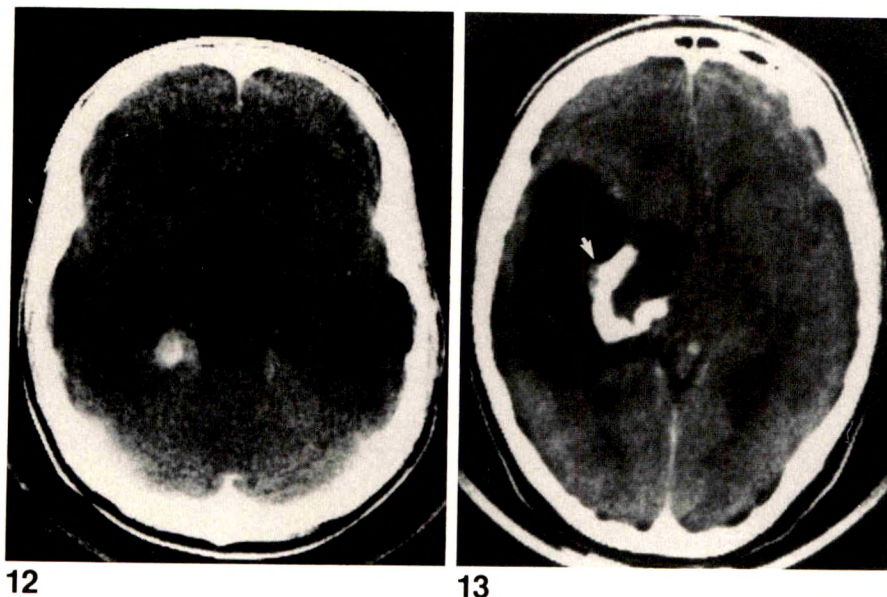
Postcontrast CT shows typical ganglioglioma presenting as a calcified and enhancing mass in the right posterior medial temporal lobe.
